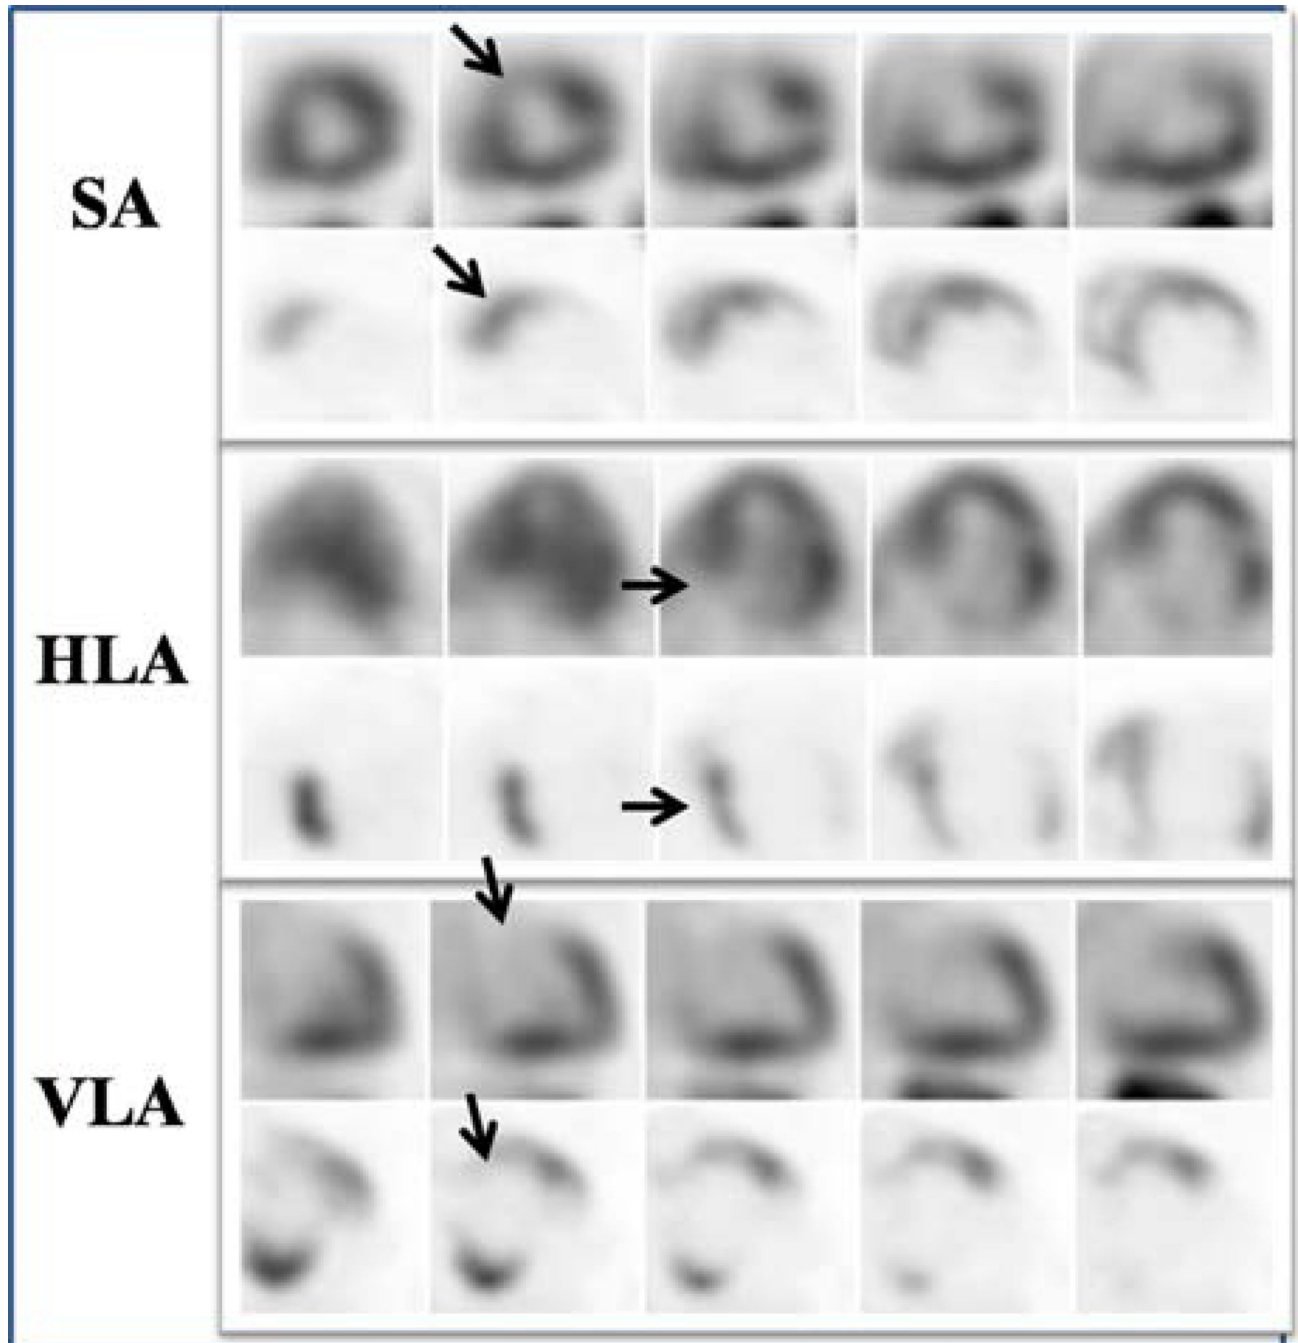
Resting ^{82}Rb PET myocardial perfusion images showing a perfusion abnormality in the basal to mid anterior and antero septal segments (*top row*). This defect is matched on ^{18}F FDG PET images by focal ^{18}F FDG PET avidity in the basal to mid anterior and antero septum (*bottom row*).
